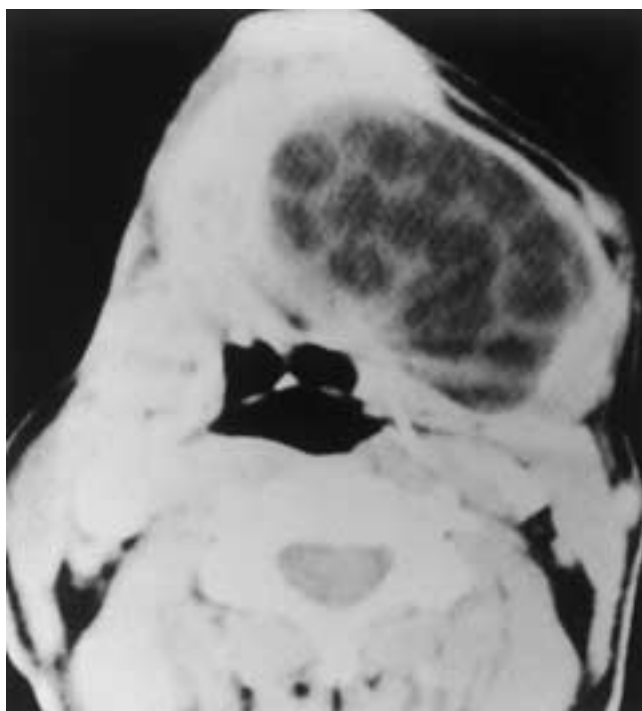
Dermoid cyst. Contrast-enhanced axial CT scans demonstrate a large lesion in the floor of the mouth that is well circumscribed and exhibits peripheral enhancement. Multiple fat globules are identified, producing a “sack-of-marbles” appearance.
